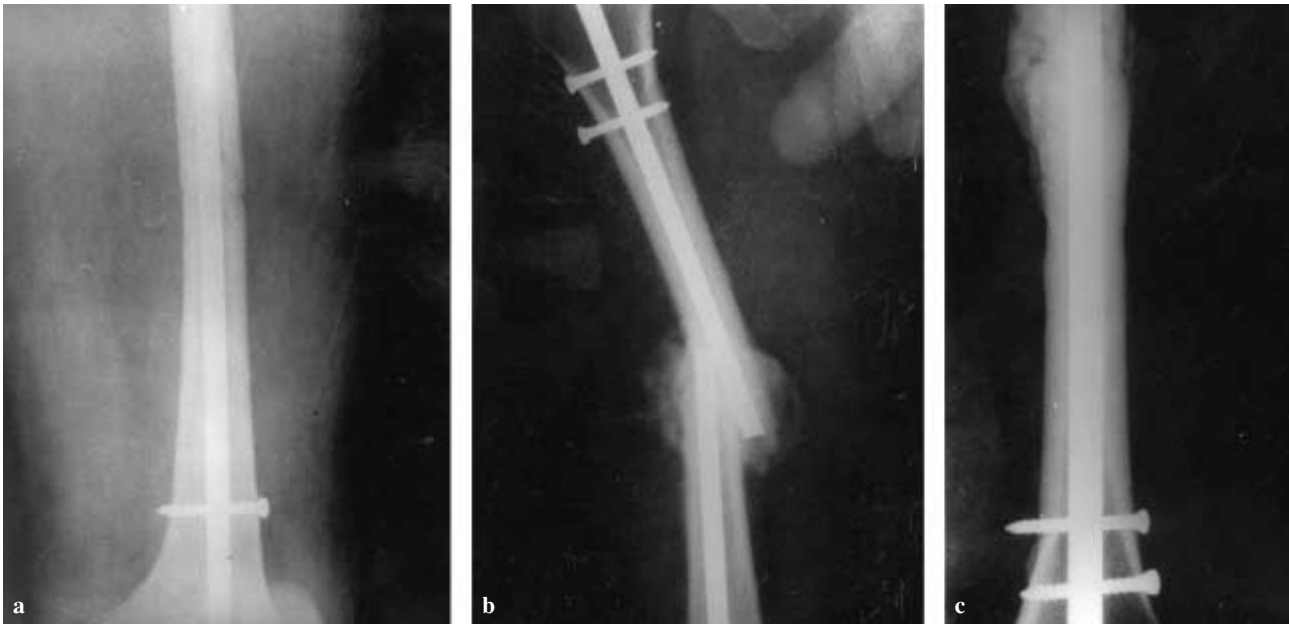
a. postoperative radiographs ; b. 30 weeks postoperative radiographs- 4 weeks after nail breakage ; c. 32 weeks after 2nd ORIF with interlocking nailing.
